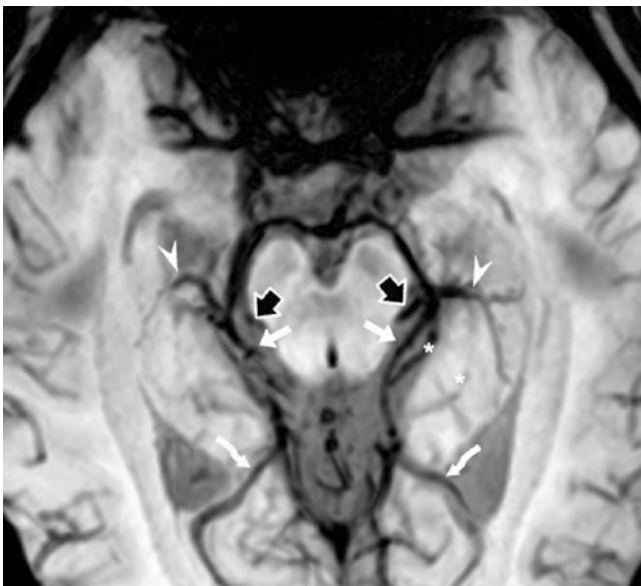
In this 27-year-old, a 3 T MRI with 10 mm thickness SWI shows the basal veins of Rosenthal (BVRs, *short white arrows*) superimposed on the posterior cerebral arteries (PCAs) (*asterisk*). The arteries are dark because of the technique (selected TE). Note the internal occipital/calcarine veins (IOVs, *curved arrows*), inferior choroidal/ventricular veins (IVVs, *arrowheads*), and lateral mesencephalic veins (*wide arrows*)
